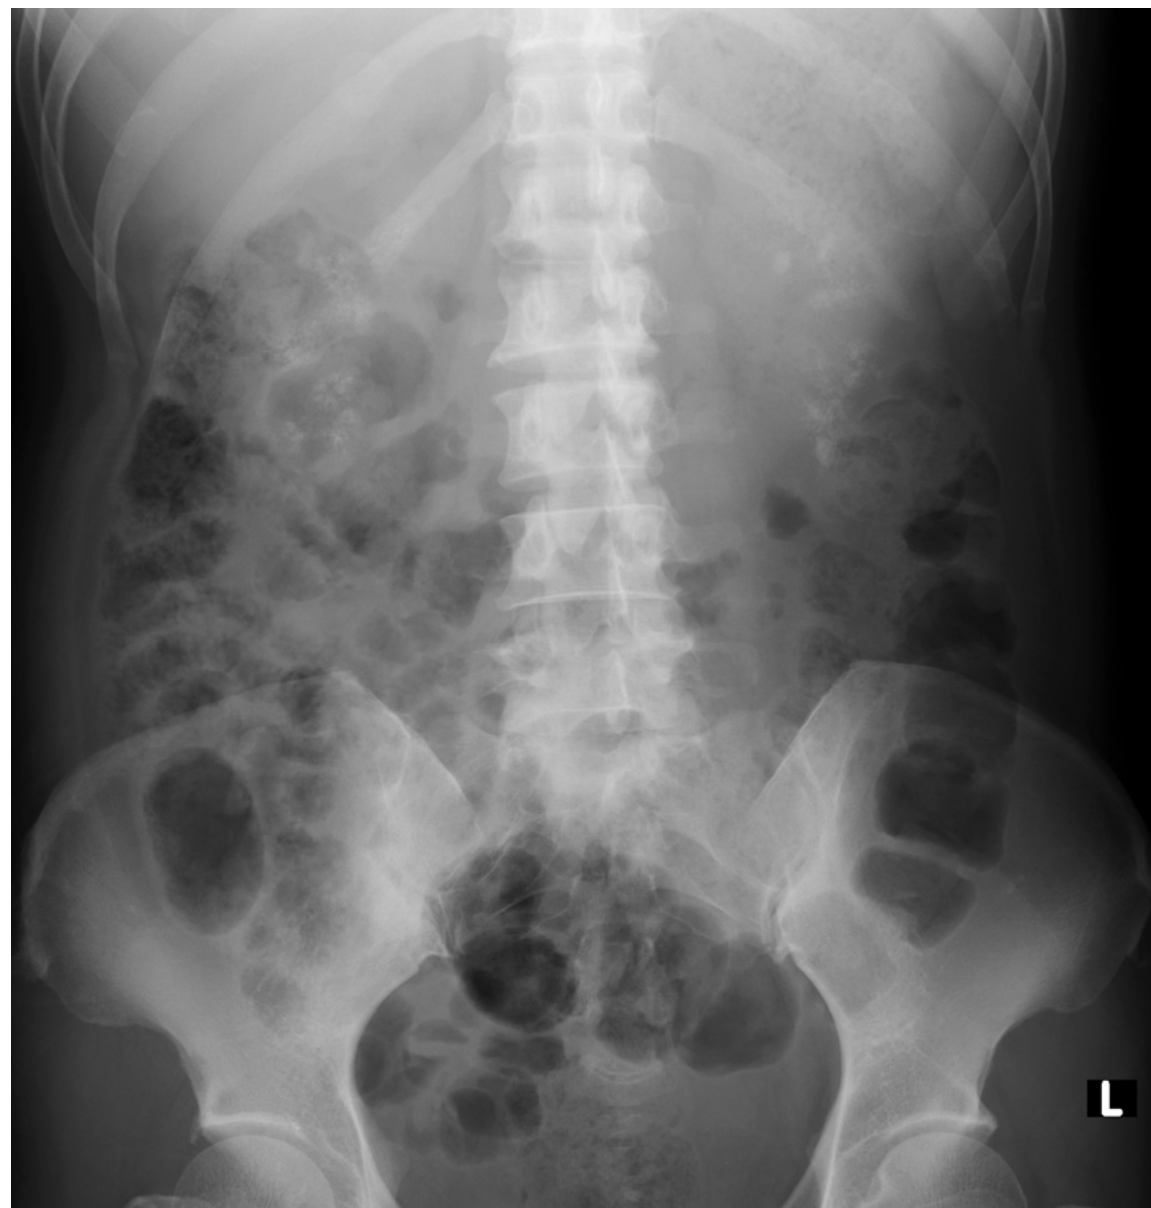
Plain radiograph of the kidneys, ureters and bladder (KUB).
